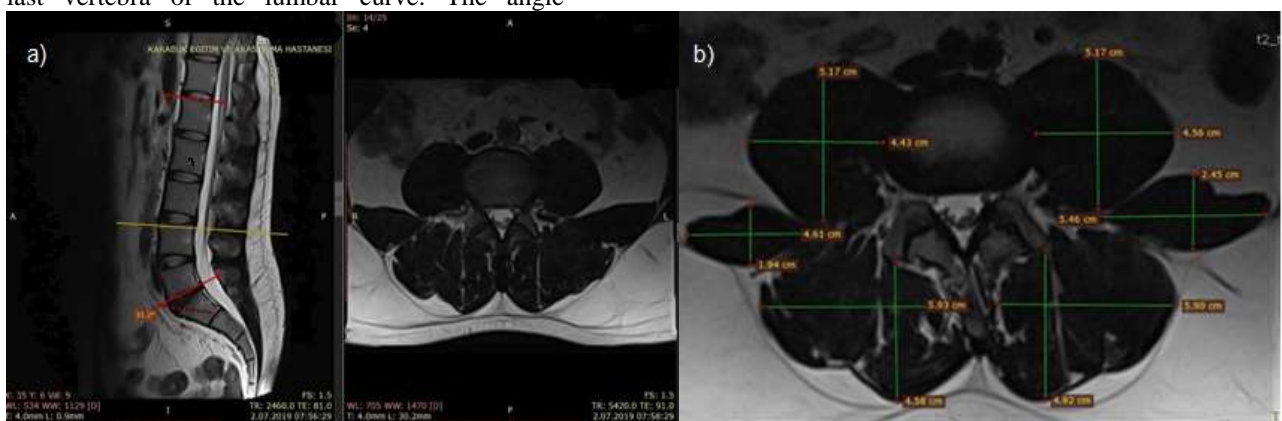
Muscle Thickness Measurement with MRI Imaging: a) T2W determination of L3-L4 level in sagittal and axial planes, b) Bilateral muscle thickness measurements
